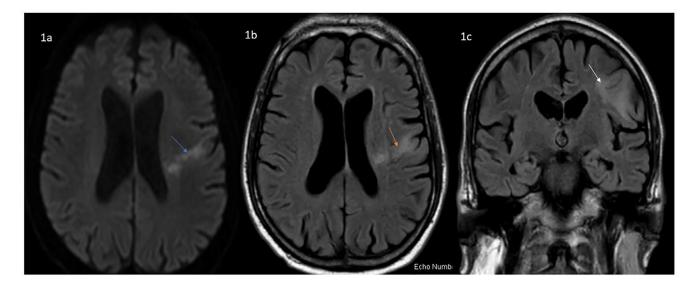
Diffusion weighted imaging axial (DWI) (1a; blue arrow), FLAIR axial (1b; orange arrow) and FLAIR coronal (1c; white arrow) revealed a 20 x 15 mm focus of restricted diffusion and hyperintense FLAIR signal of what appeared to be an acute to subacute ischemic infarction in the left precentral gyrus extending to the left thalamus found on early presentation
